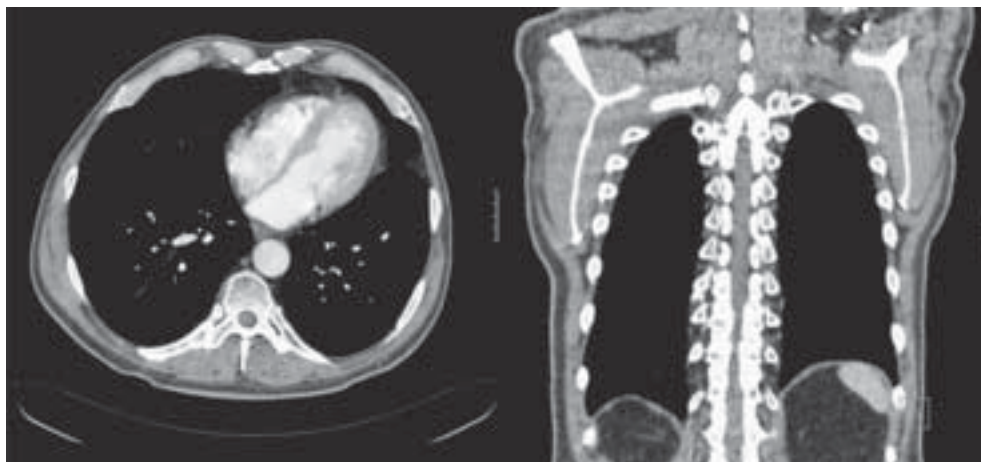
Chest CT, March 2010. Small fibrotic lesions in supradiaphragmatic segments of both lungs, no apparent metastases, no enlarged lymph nodes of the hili and mediastinum
